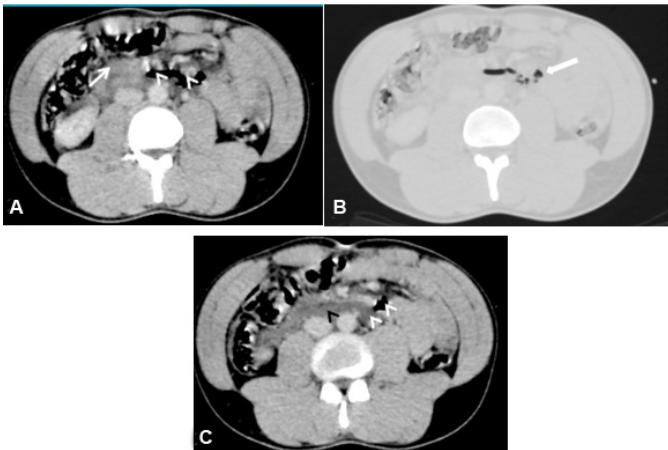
Axial contrast enhanced CT abdomen in soft tissue window (A, C) and lung window (B), demonstrating a clear discontinuity in the duodenal wall with fluid collection both in front and behind the duodenum (>), along with extra-digestive air bubbles (B with arrow). The wide breach is outlined by the gas bubbles (>). Take note of the mesenteric hematoma (→).
